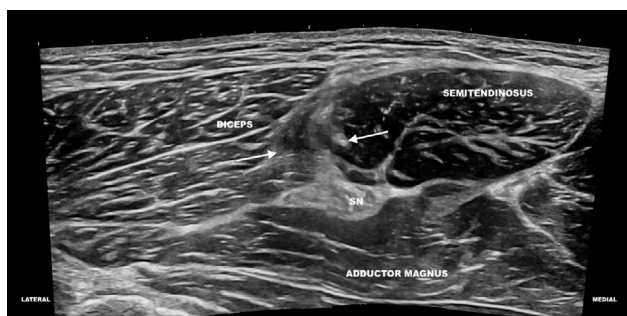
A 17-year-old male complained of a posterior soreness in the thigh after a match. An ultrasound image in the transverse plane of the semitendinosus and biceps muscles showing architectural distortion of both muscle fascicles, disruption of the conjoint tendon (arrows), and a partial tear of the semitendinosus aponeurosis. SOMICS category 3 (score of 8).
